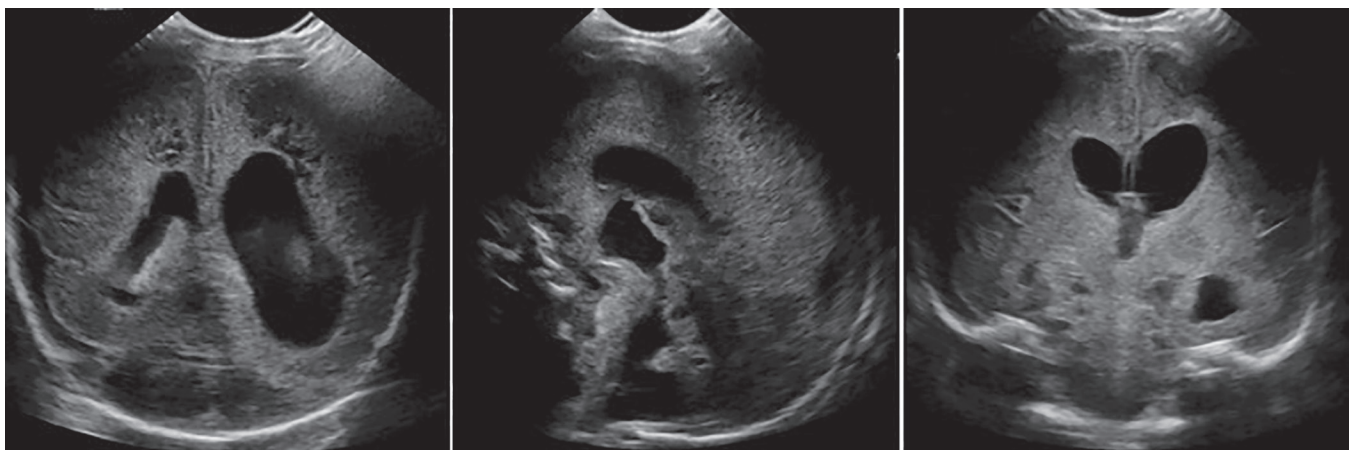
Head ultrasound images showing poor differentiation between gray and white matter, ventriculomegaly of the lateral and third ventricles, an absent corpus callosum, punctate foci of echogenicity near the left vertex concerning for ischemia versus hemorrhage, and a malformed cerebellum.
